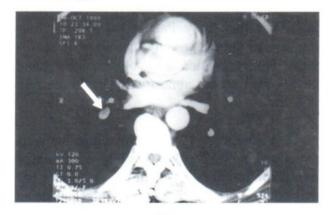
Filling defect in right segmental pulmonary artery supplying RLL in CTA (arrow)
